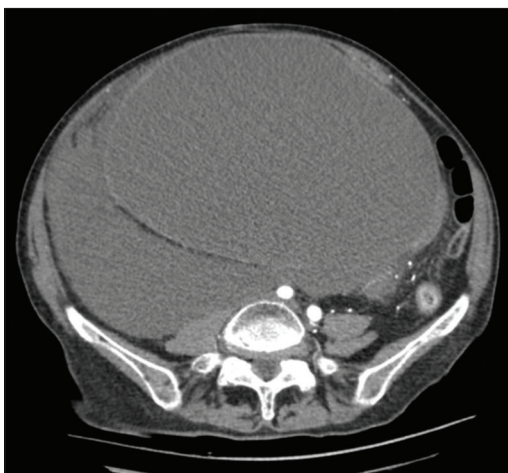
CT scan performed upon patient arrival at A and E. We can point out the enormous pyelocaliceal dilatation of the right kidney and the markedly thinned renal cortex and poor concentration of iodized urine ipsilaterally. At the CT scan we also noticed marked compression on the liver with associated dilatation of the intra and extra hepatic bile ducts (maximum dilatation of about 12 mm of the bile duct). Front compression and a left pancreas with mild Wirsung duct ectasia. CT: Computed tomography
